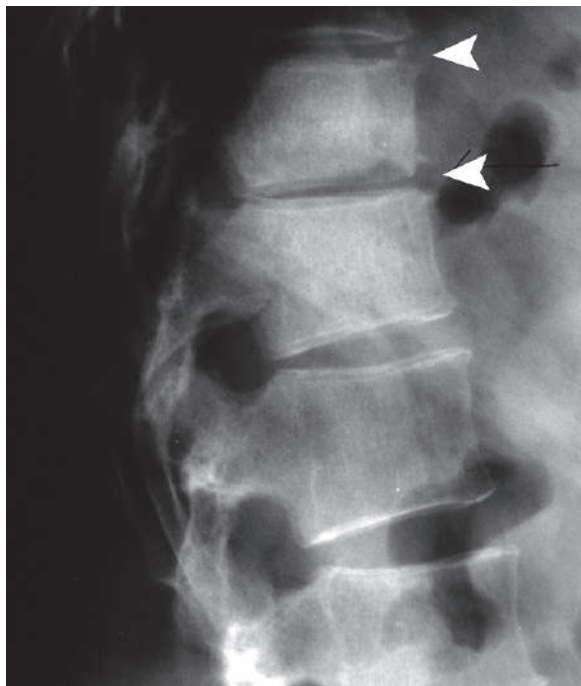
Lateral plain radiograph of the lower thoracic vertebrae in a patient with brucellosis shows spondylitis affecting the anterior-superior and the anterior-inferior vertebral end plates (arrowheads)
